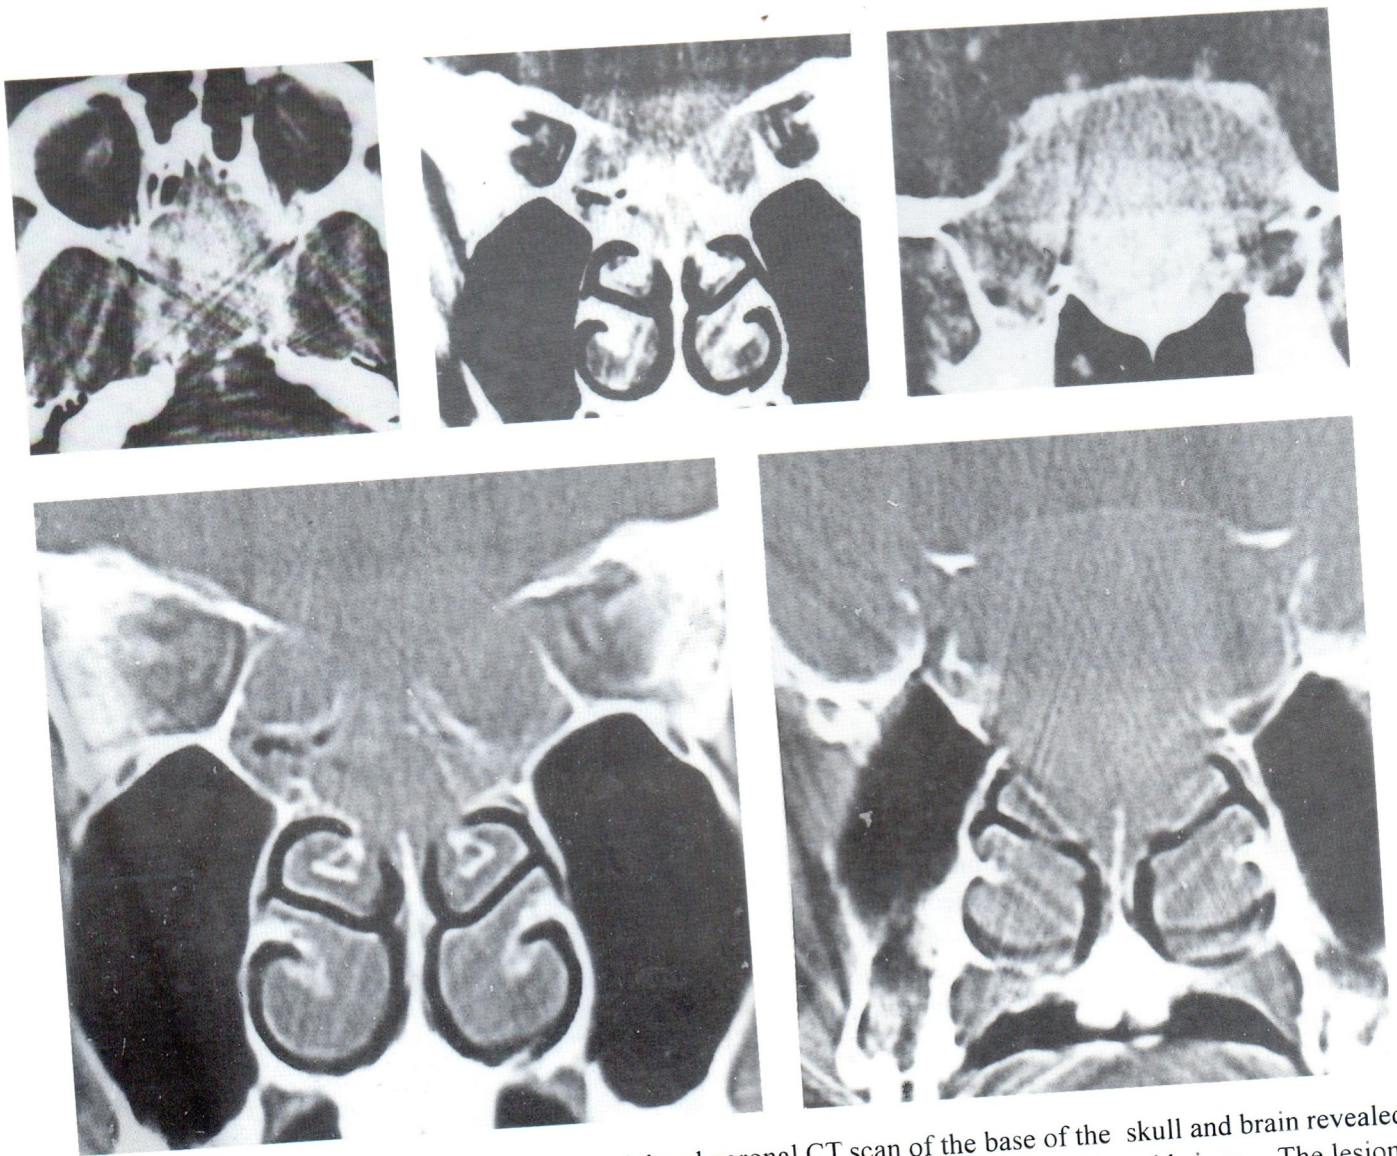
Case 4. Post contrast enhanced axial and coronal CT scan of the base of the skull and brain revealed a homogeneous hyperdense soft tissue lesion in the expanded sphenoid sinus. The lesion extended to both sides of the cavernous sinuses. Bony destruction was noted at clivus, superior part of left pterygoid plates, walls of the sphenoid sinuses and bony parts of the skull base.
